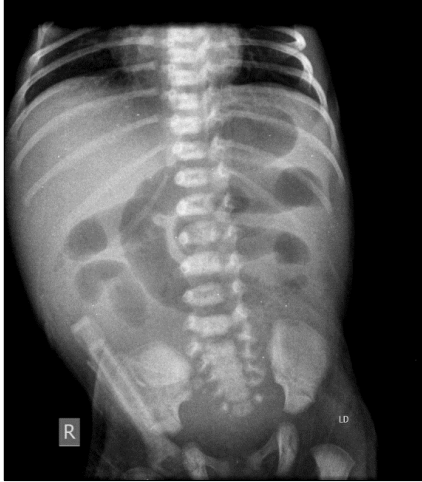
X-ray abdomen showing features of small intestinal obstruction
